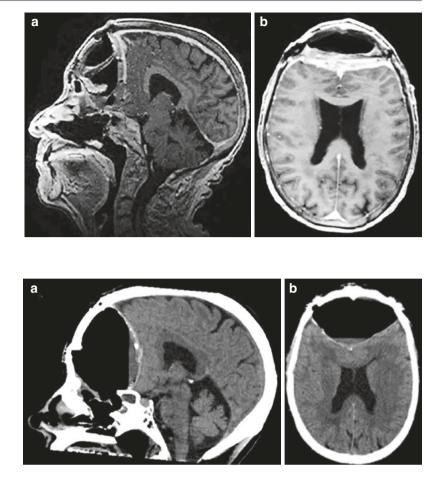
Computed tomography in sagittal (a) and axial (b) planes 8 weeks after the resection of esthesioneuroblastoma demonstrates large epidural hypertensive pneumocephalus but no intradural air
